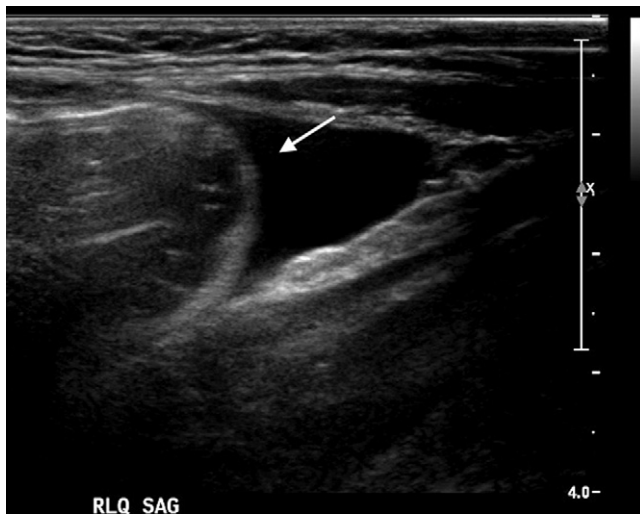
Ultrasonography showing tip of intussusception (arrow) in longitudinal plane just deep to the anterior abdominal wall.
